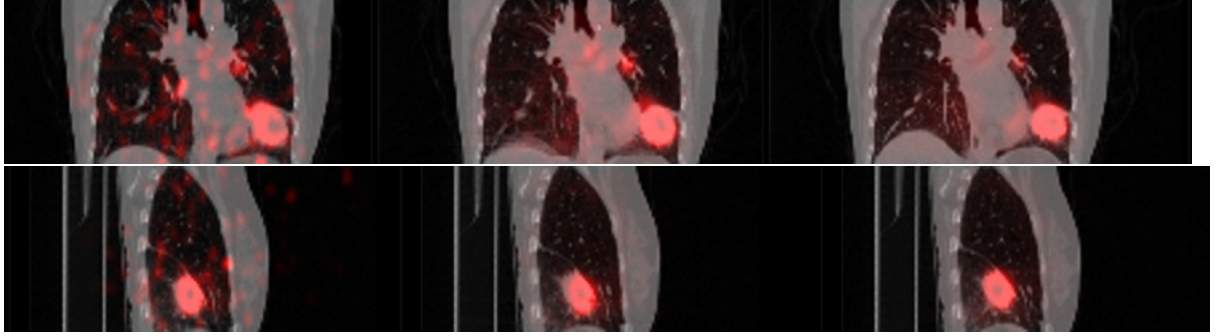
Patient 3. Coronal (top) and sagittal (bottom) fused PET and CT images, bins 2, 5, 8 (left to right).
